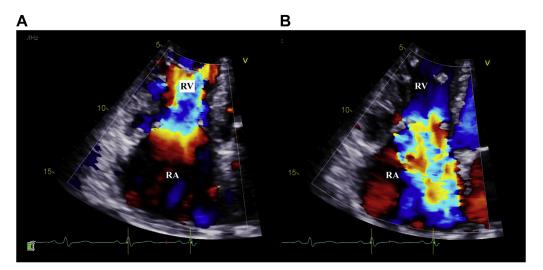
Magnified, color Doppler TTE oriented in an apical four-chamber view showing turbulent tricuspid inflow with trivial stenotic physiology (A) and severe TR (B).
